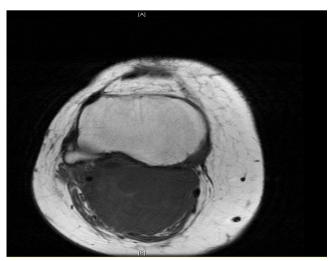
Cross sectional MRI view of the right knee showing the popliteal mass
